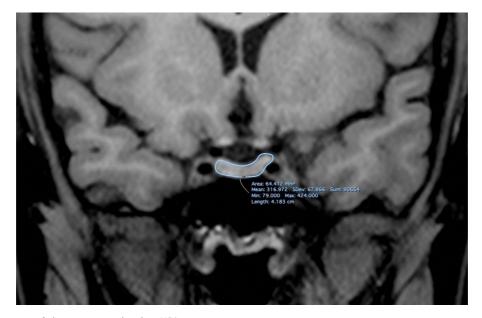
Sample trace of the pituitary gland in MRI.
